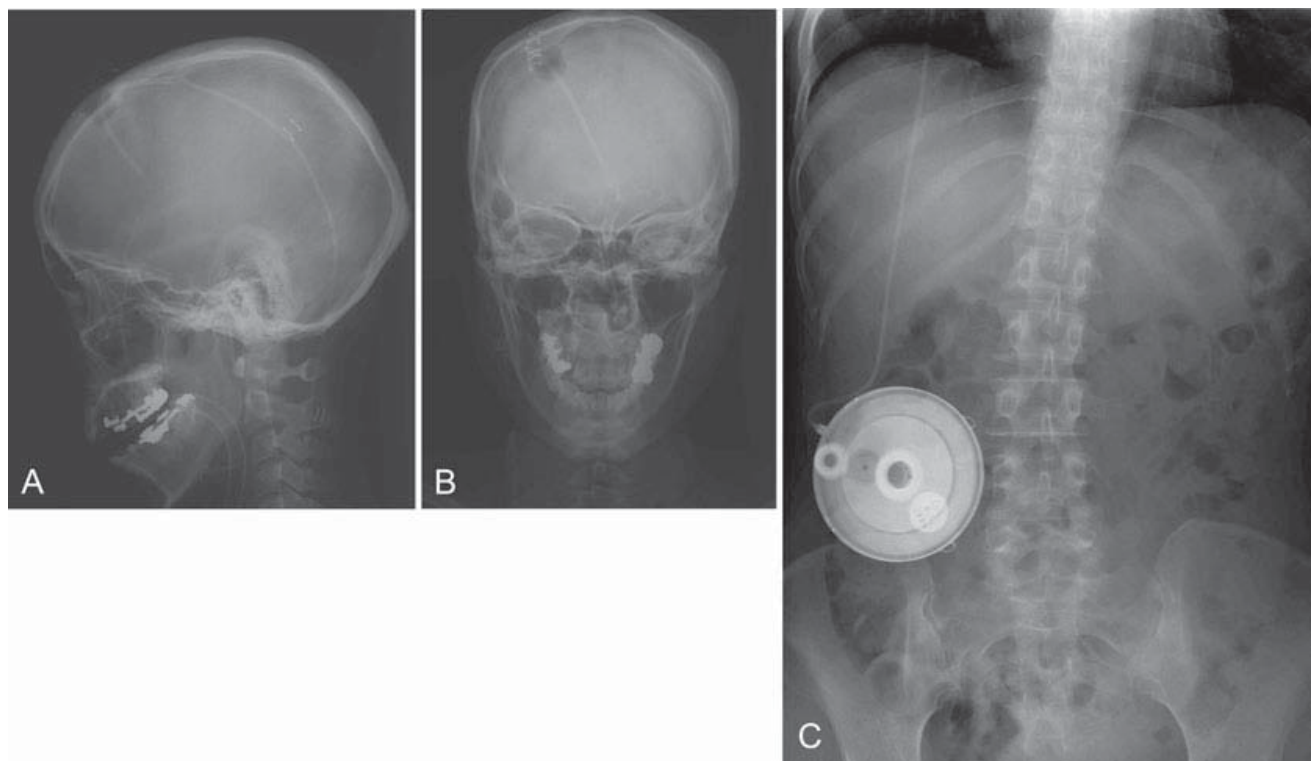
(a,b) Skull X-ray shows a catheter inserted in the lateral ventricle. (c) Abdominal X-ray shows implanted pump on the abdominal wall and a catheter connected from the pump under the skin.
